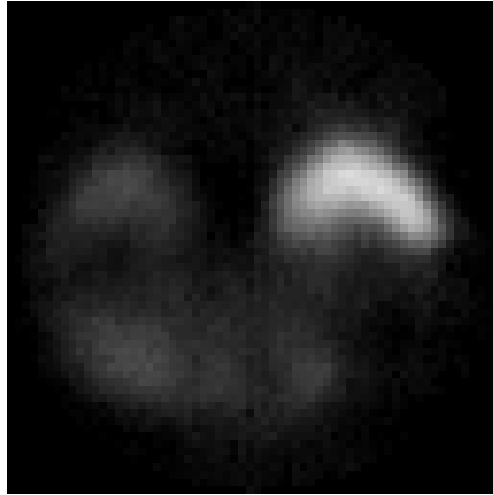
A SPECT image of the liver. This is one of 64 slices constituting a 64^3 SPECT volume produced by a Gamma-11 camera, the Octreoscan tracer at Dept. of Oncology, Sect. of Nuclear Medicine, Uppsala University Hospital. (By courtesy of Jan-Erik Westlin.)
